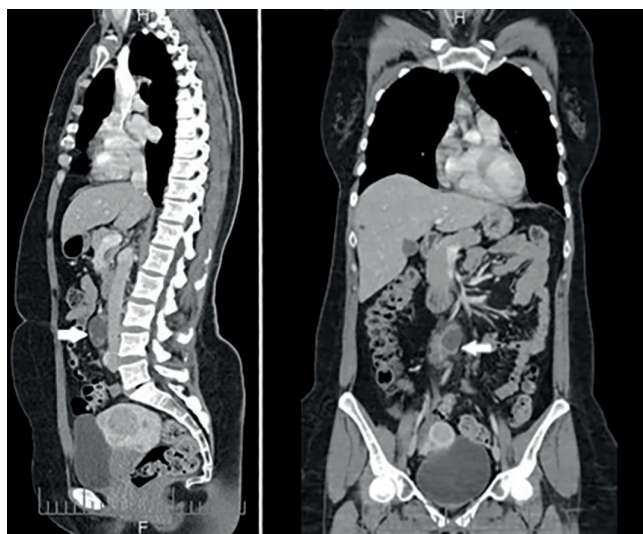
CT images of precaval retroperitoneal PEComa (sagittal and frontal slides)
